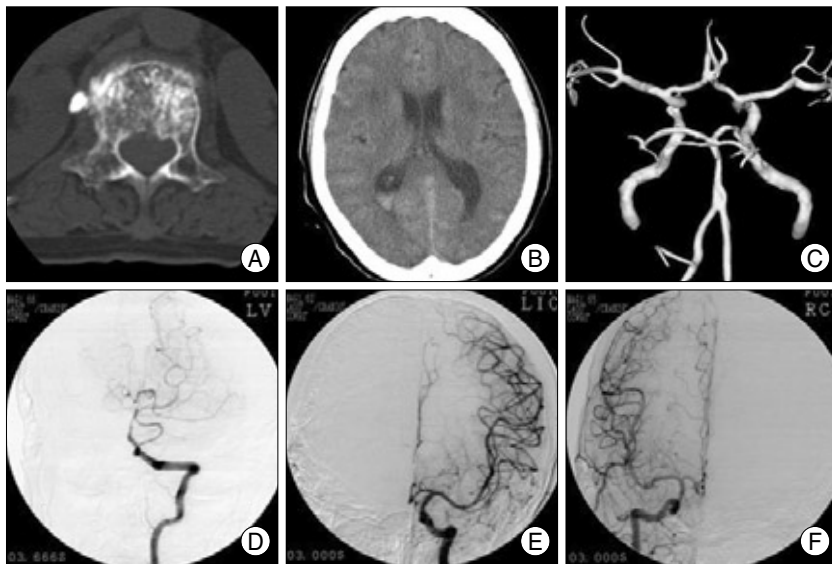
A 65-year-old woman who complicated with nonaneurysmal subarachnoid hemorrhage following percutaneous vertebroplasty. Cement was leaked into the paravertebral muscles (A). Computed tomography after spine intervention shows subarachnoid hemorrhage and ventricular hemorrhage (B). Vascular lesions on the both carotid and vertebrobasilar trees except basilar artery fenestration are not detected on magnetic resonance angiography (C) and catheter angiography (D, E and F).
